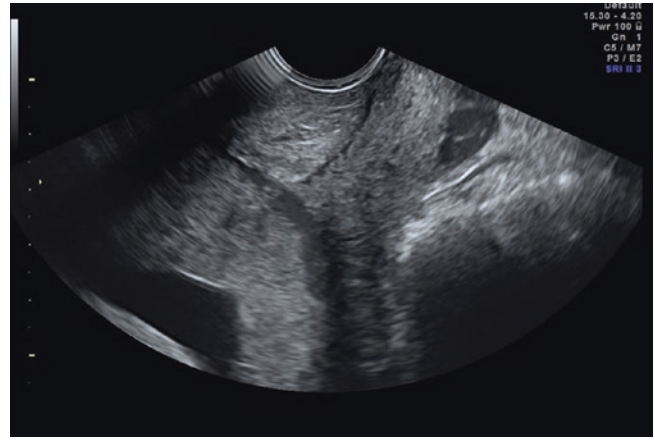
The placental edge overlaps the internal cervical orifice by more than 2 cm at transvaginal ultrasound
